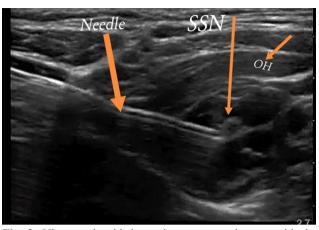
Ultrasound guided anterior suprascapular nerve block. SSN: Suprascapular nerve; OH: Omohyoid muscle.
